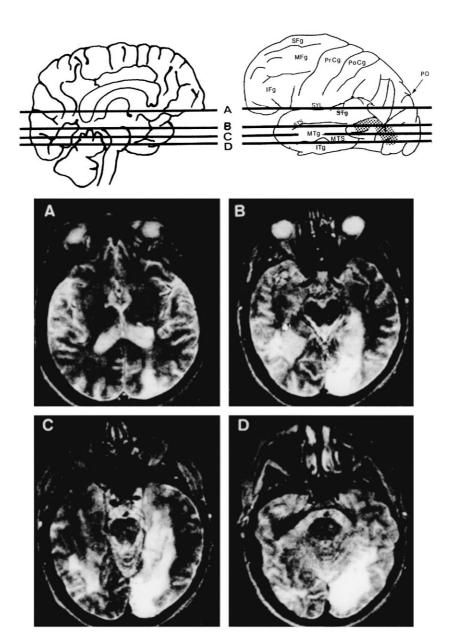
A, B, C and D show four MR images through the brain of patient AL at the levels indicated on the medial (top left) and lateral (top right) views of one hemisphere. The scan was obtained one week after the large haemorrhage of her left hemisphere but three years after the much milder stroke caused by the very restricted lesion of her right hemisphere and whose consequences are the subject of this paper. The medial view, top left, is drawn from a near-midline parasaggital image but the temporal lobe, which is not visible so close to the midline, was added by hand. The lateral view is of a standard human brain at the same scale. The stippled area in the lateral view shows the projection onto the lateral surface of the largely white matter lesion in AL's right hemisphere. This small, and older lesion, is present on slices B,C and D and involves the cortex near the lateral surface only at the caudal end of the lesion (D). The later and much larger lesion, which led to a complete hemianopia and is not discussed in this paper, is present in all four images. Following radiographic convention, the right hemisphere is shown on the left, including the surface views at the top. Abbreviations: SFg, MFg, IFg, superior, middle and inferior frontal gyri respectively; STg, MTg, ITg, superior, middle and inferior temporal gyri; PrCg, PoCg, pre-and post central gyri; PO, parieto-occipital sulcus; SYL, Sylvian sulcus; STS, superior temporal sulcus.
